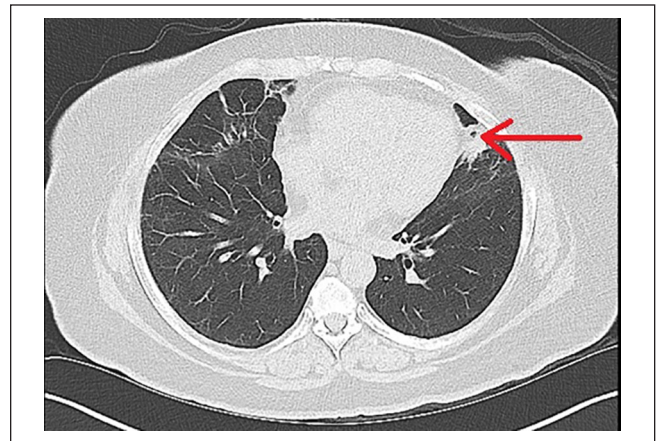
CT of the chest without contrast in April 2021 which showed an elongated lingular nodule (red arrow) which previously appeared as a cavitation of the left lung. Abbreviation: CT, computed tomography.
